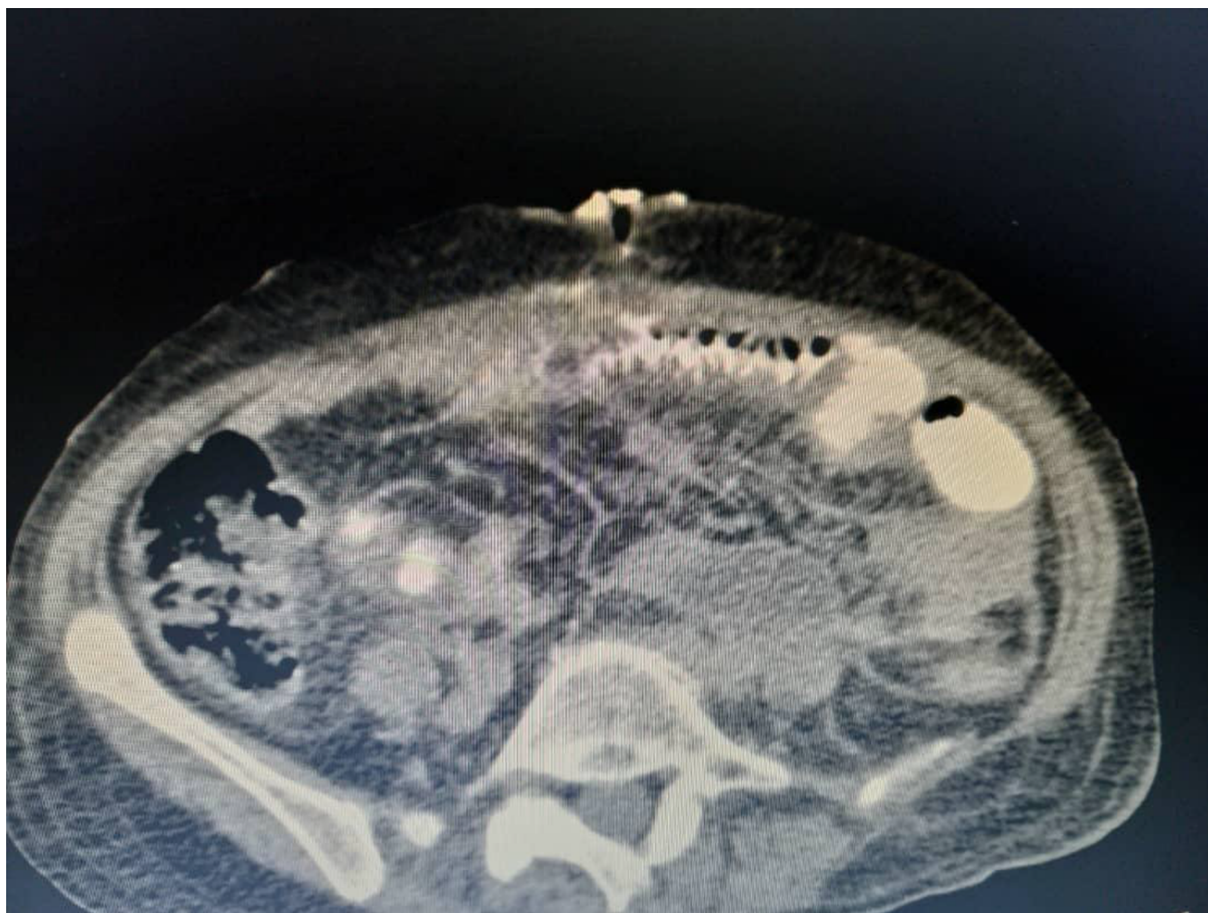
Computed tomography with leakage far from the anastomosis in the jejunum
